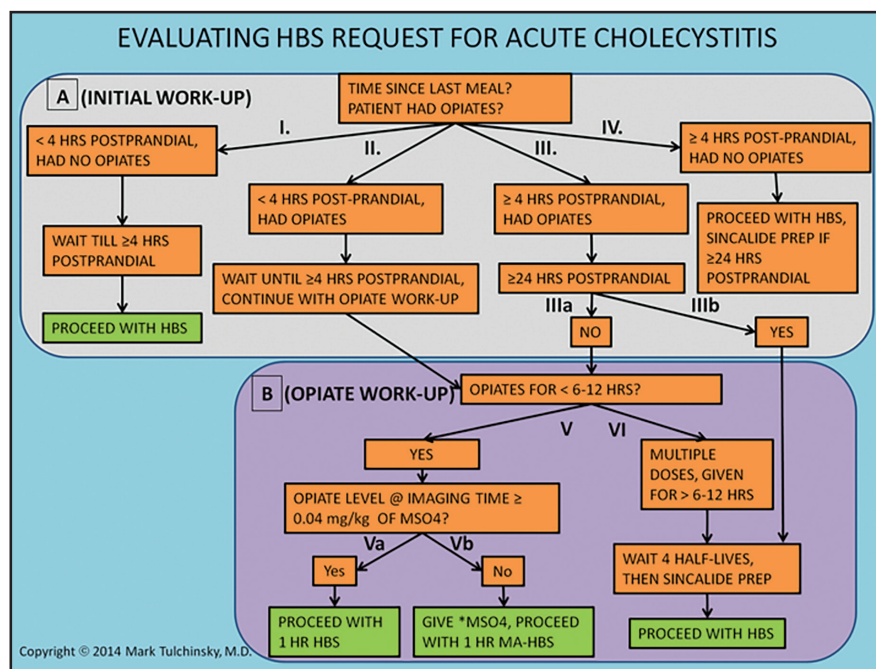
Evaluating request for hepatobiliary scintigraphy (HBS).
